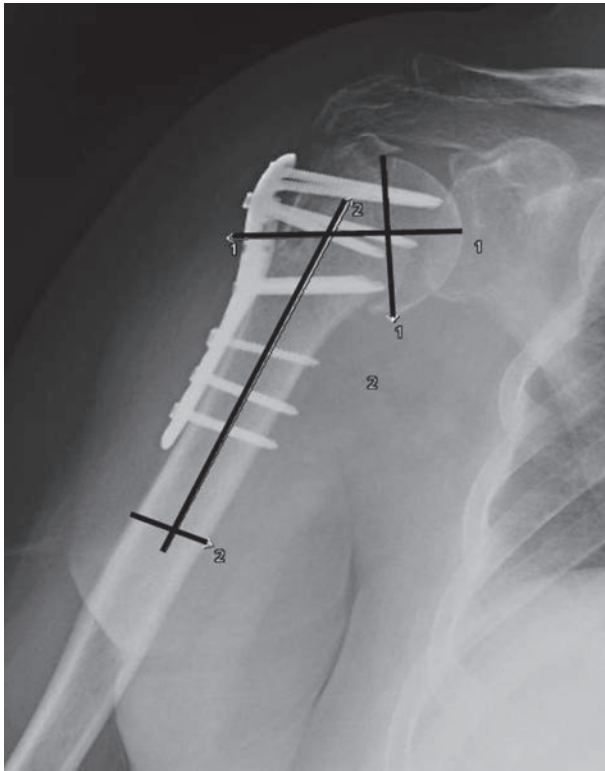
Radiograph at 3 months of follow-up (HHSA 115,49°) showing further loss of reduction.
